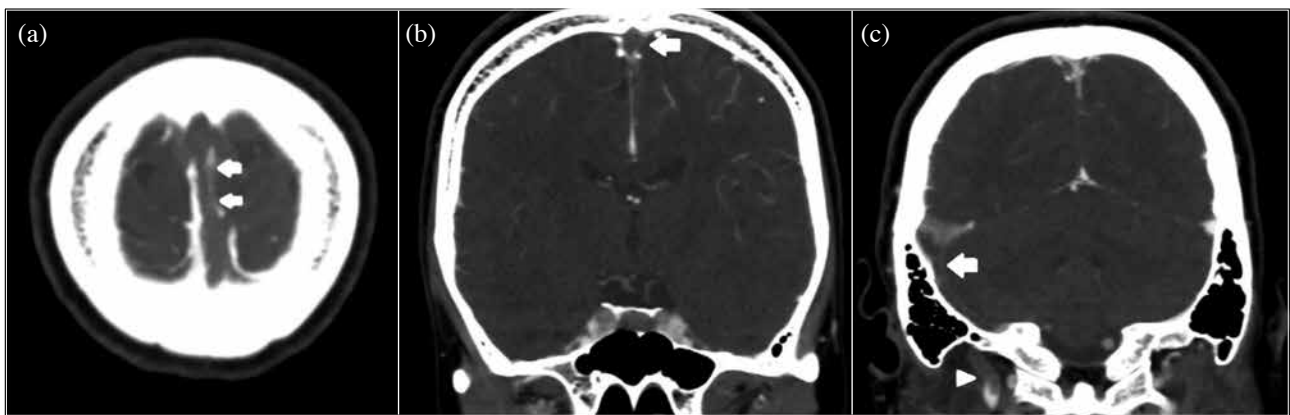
Computed tomographic venography showing filling defects at the (a and b) superior sagittal sinus, with the 'empty delta sign' (arrow) and (c) right transverse and right sigmoid (arrow) sinuses extending to the origin of the right internal jugular vein (arrowhead). The diagnosis of cerebral venous sinus thrombosis is confirmed.
